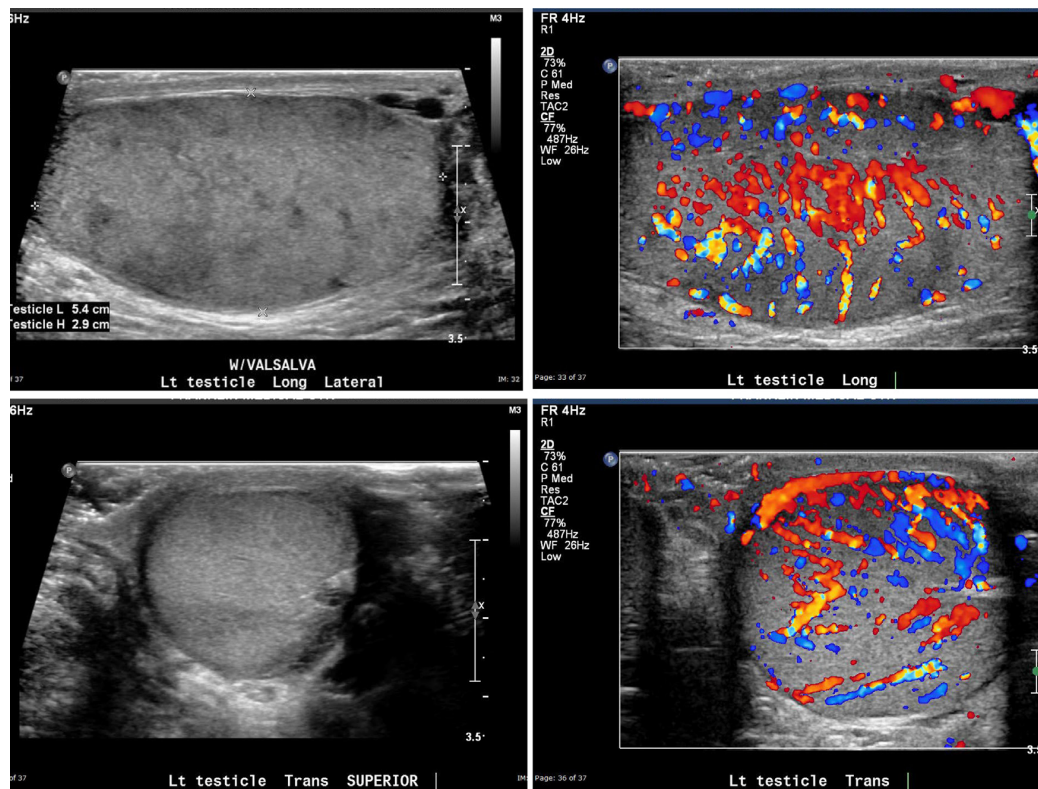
Orchitis: hyperemic, mottled testicular echotexture with hypoechoic regions. Color doppler images show testicular hyperemia. This is often the result of spread from pre-existing epididymitis (not shown), rarely when isolated to the testicular parenchyma without associated epididymitis. This entity is known as orchitis and may be secondary to mumps. (Color version of figure is available online.)
